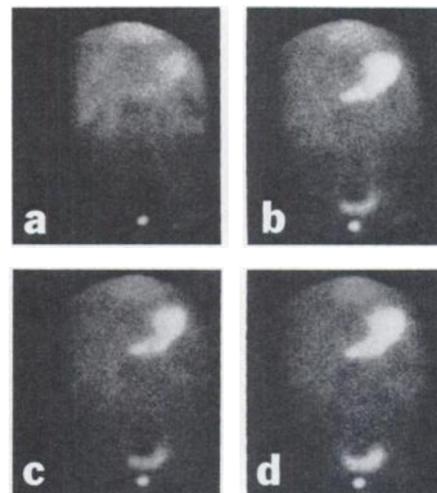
Negative pertechnetate scintigrams in a 5-year-old boy at 10 min (a), 20 min (b), 40 min (c), and 60 min (d) after injection of pertechnetate.
